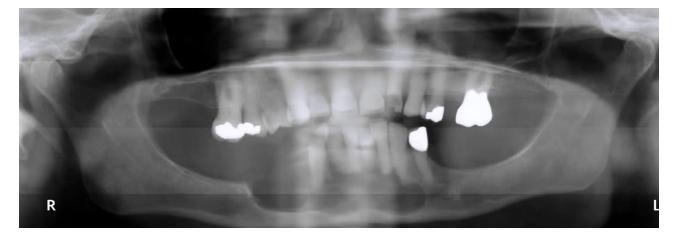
Initial presentation X-rays showed a large, radiolucent anterior mandibular lesion.
